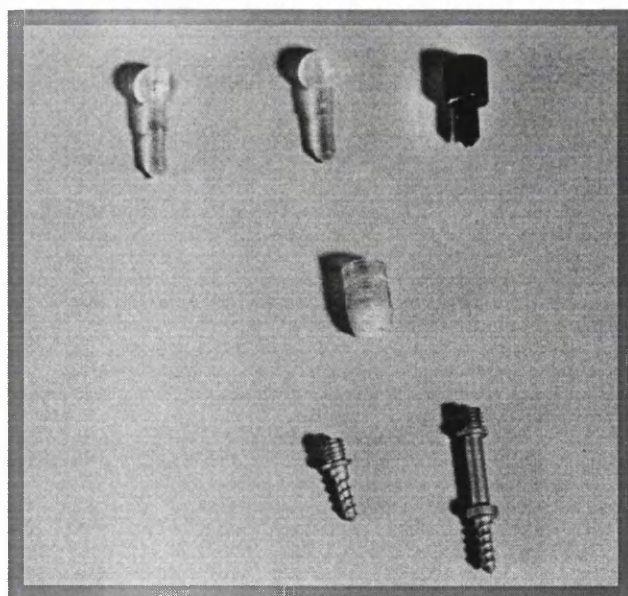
The image localiser screw system. CT, MRI and intra-operative localiser attachments are shown above. The universal cup attachment lies in the centre and screws of two lengths are shown below.
